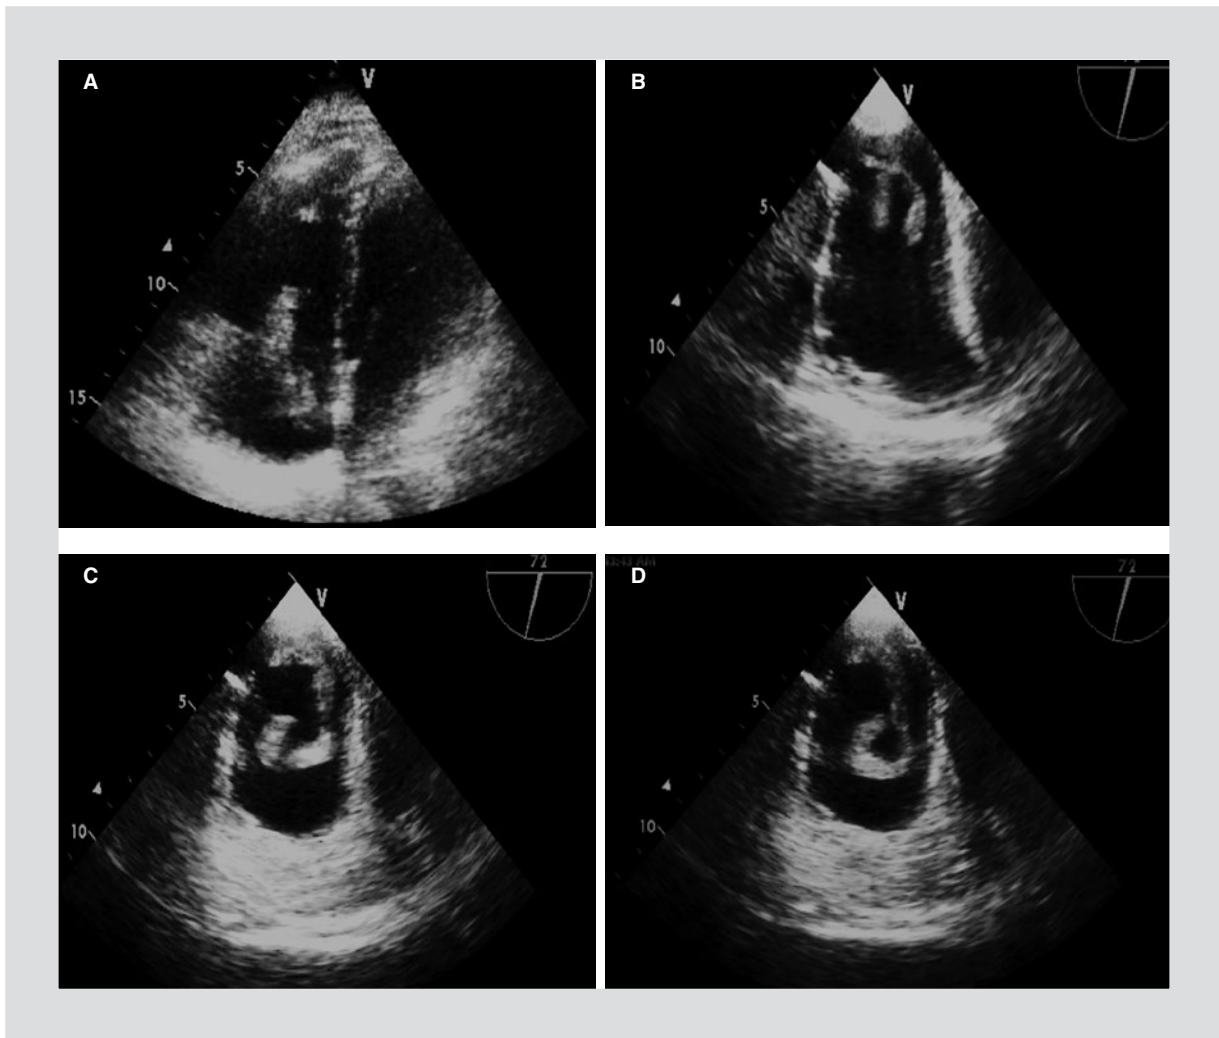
A: transthoracic echocardiogram showing a thrombus in the right atrium protruding towards the right ventricle. B, C and D: transesophageal echocardiogram showing a worm-like structure in the right atrium adhered to the Eustachian valve.
